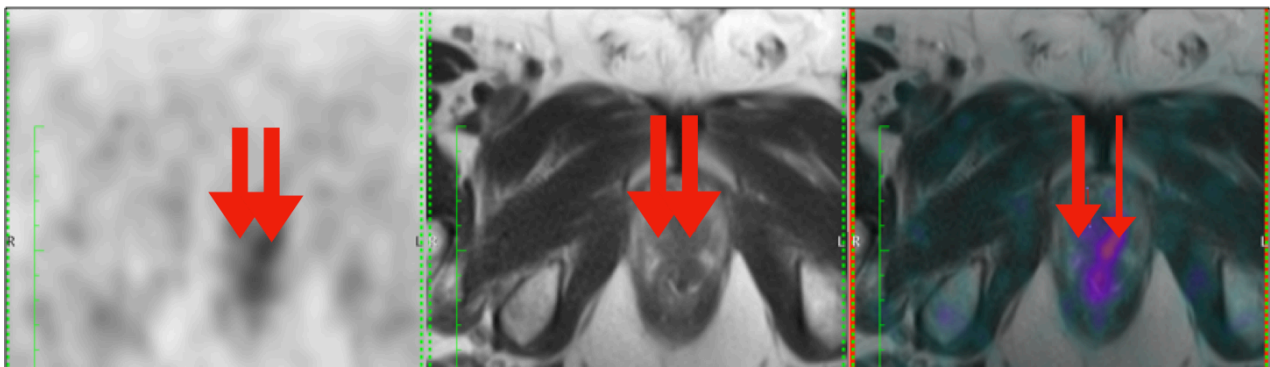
^{18}F Choline PET/MR (from left to right) axial PET, MR and fused axial PET/MR. This patient presented with history of biochemical relapse following radiotherapy (PSA 2.67). There is asymmetrical increased tracer uptake in the left lobe of the prostate (SUVmax left lobe 3.6 and right lobe 1.8). TPM revealed adenocarcinoma in the left lobe with MCCL of 7mm and TCCL of 14mm. No evidence of malignancy in the right lobe.
